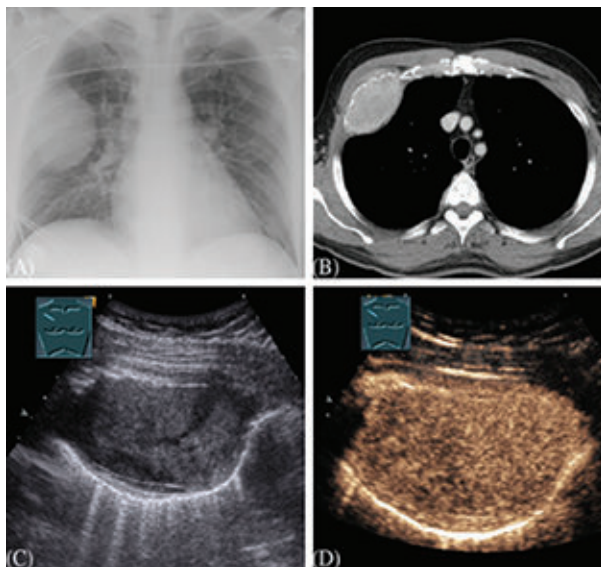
Contrast-enhanced ultrasound reveals a hyperechoic, homogeneous enhancement of the lesion after 31 s. An ultrasound-guided biopsy was performed, with the diagnosis of plasmocytoma. (Courtesy of Prof. Dr. Mahnken, Department of Radiology, University hospital Marburg)
